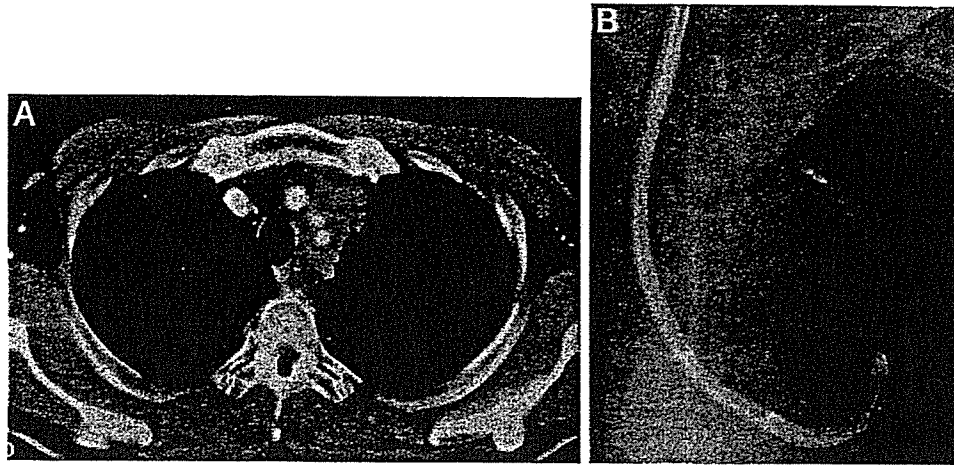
Case 3: NSCLC. *Left, A:* a chest CT scan reveals a mediastinum-involved tumor shadow on the left side. *Right, B:* a bronchoscopic image shows the STAF approaching the tumor through the left B3c.
